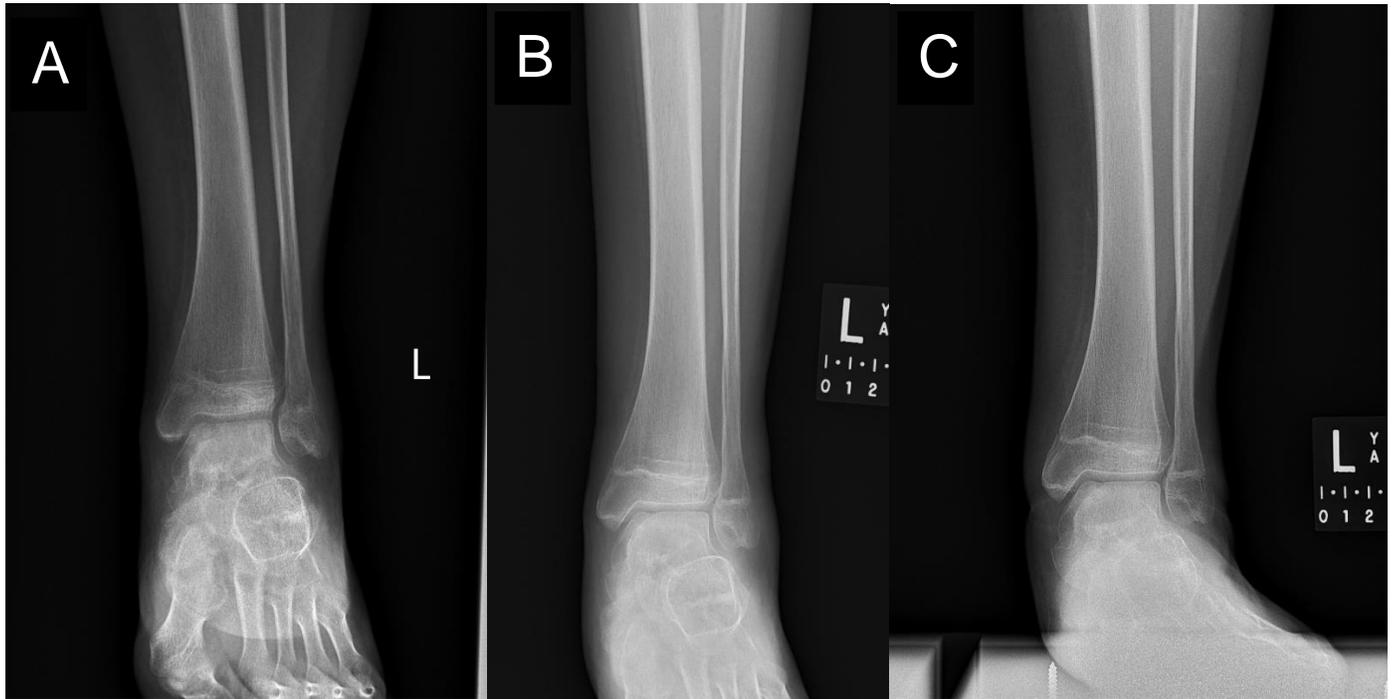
Post-operative A) 1 month B) 3 month and C) 6-month plain film radiograph showing the healing progress to the previous medial talar dome OCD.
